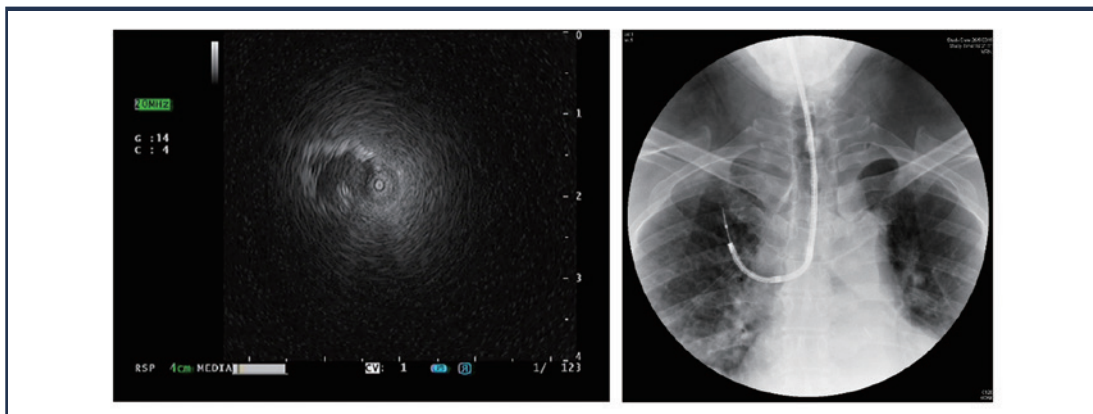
Positive radial EBUS signal (left) showing the lung nodule as an ~8mm x 5mm hypo-echoic area at the 9 o'clock position relative to the probe. The corresponding fluoroscopic image (right) displays the position and maximum depth of a thin bronchoscope, approximately 3 cm away from the target, alongside the radial EBUS probe's location when the positive ultrasound signal was detected. (Personal collection)
